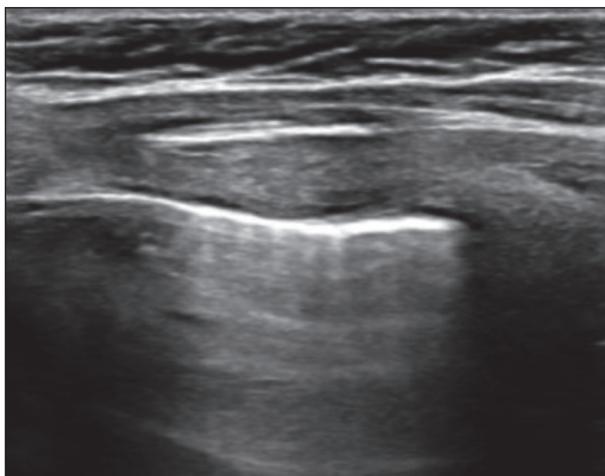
Lung Ultrasound of a 6-year child with Covid-19 and admitted for fever and cough. Vertical artifacts, named B lines, are shown, with increased thickness of pleural line.
